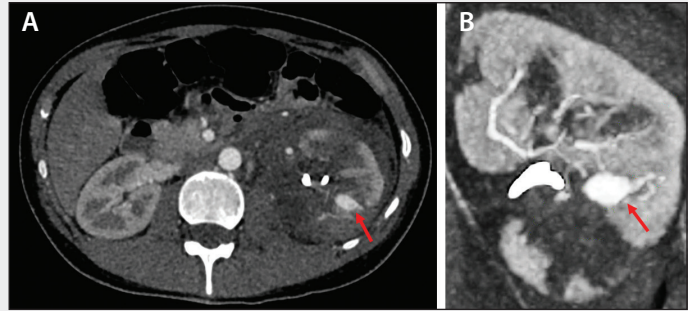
Arterial phase CT scan (left axial section, right coronal section focused on the left kidney) performed the next day showing a large pseudoaneurysm in the left interpolar region (red arrow) (A). The top of the ureteric stent is partially imaged (B).
